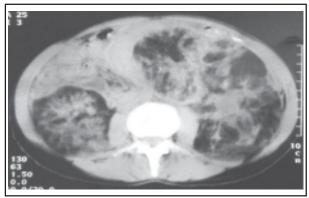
Bilateral renal angiomyolipomas in abdominal CT scan.
